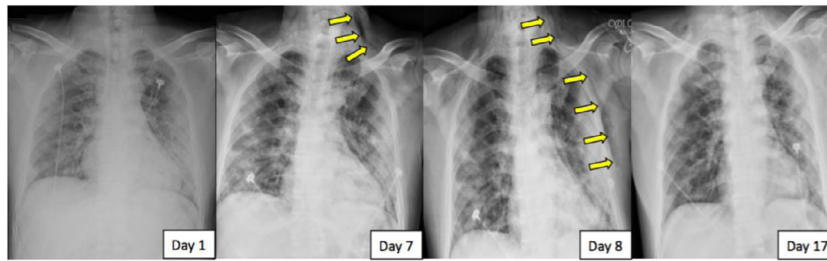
Changes in chest radiographs during hospitalization. (a) Infiltration in the bilateral lung fields on Day 1. (b) Pneumomediastinum and emphysema in the left side of the neck on Day 7. (c) Pneumomediastinum and emphysema in the bilateral lower sides of the neck and bilateral chest walls on Day 8. (d) Pneumomediastinum and emphysema had disappeared gradually in the bilateral lower neck area and bilateral chest walls by Day 17.
